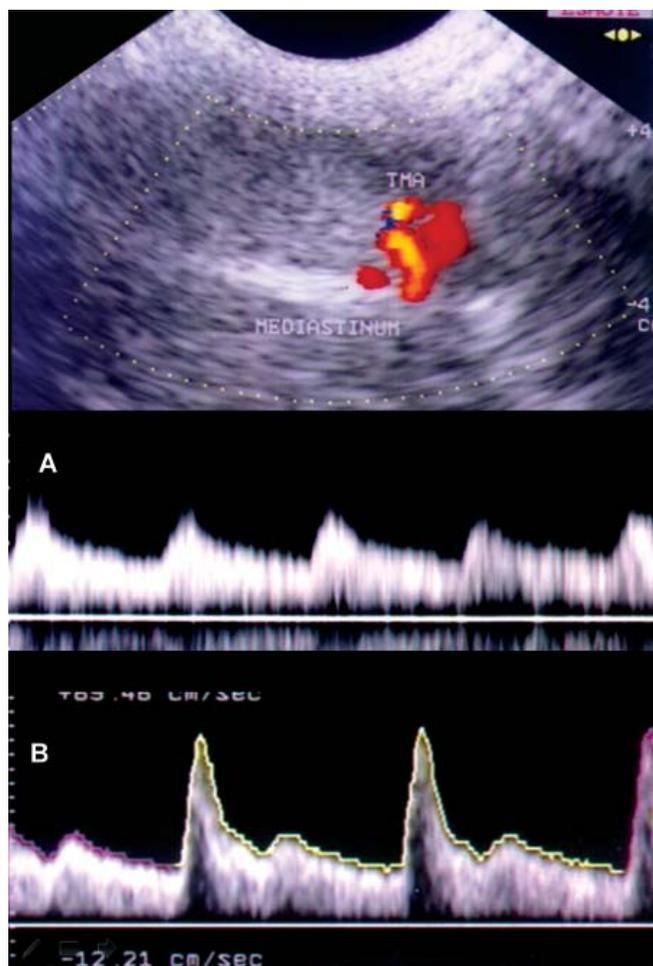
Color Doppler analysis of the transmediastinal artery: (A) Normal vascularization in controls, (B) increased resistances in male survivors of childhood malignancies
